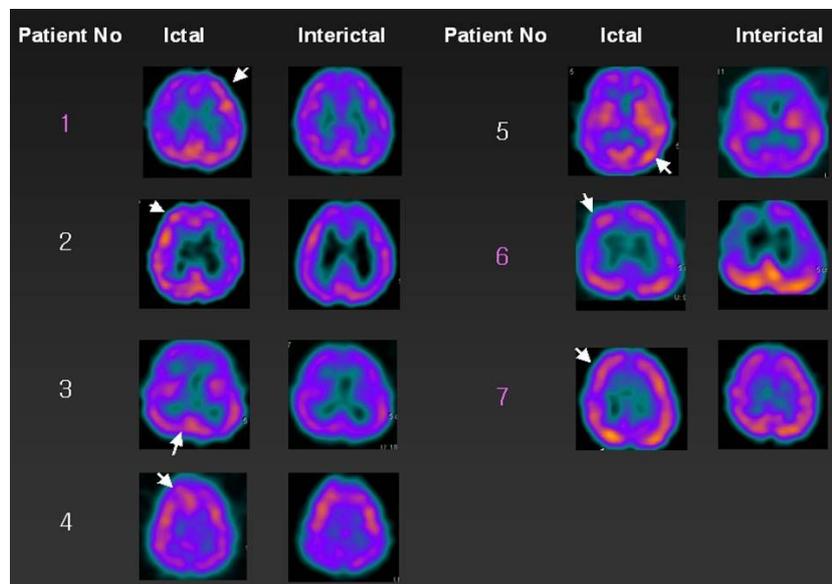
Visual analysis of interictal and ictal single-photon emission computed tomography (SPECT) images of patients with infantile spasms.
